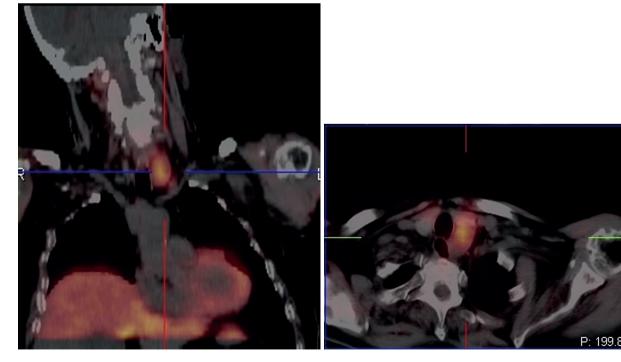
SPECT-CT images of the paratracheal mass characterized by a markedly increased 99mTc-MIBI radiotracer accumulation.
